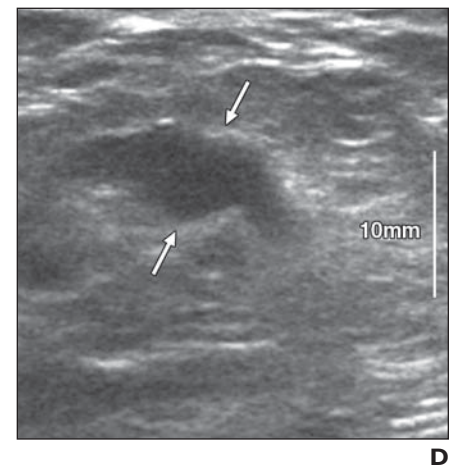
Ultrasound images of 72-year-old woman with infiltrating ductal carcinoma.
